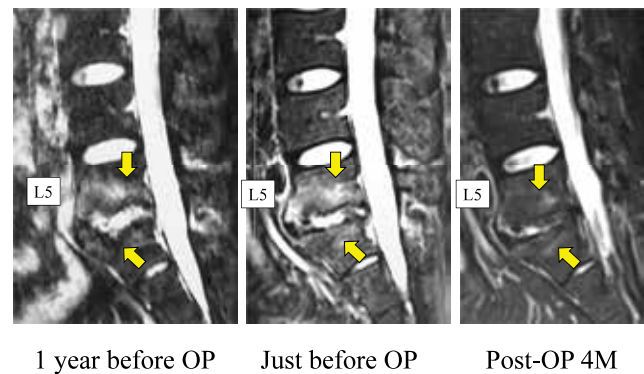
Time course of STIR-MRI before and after OP
